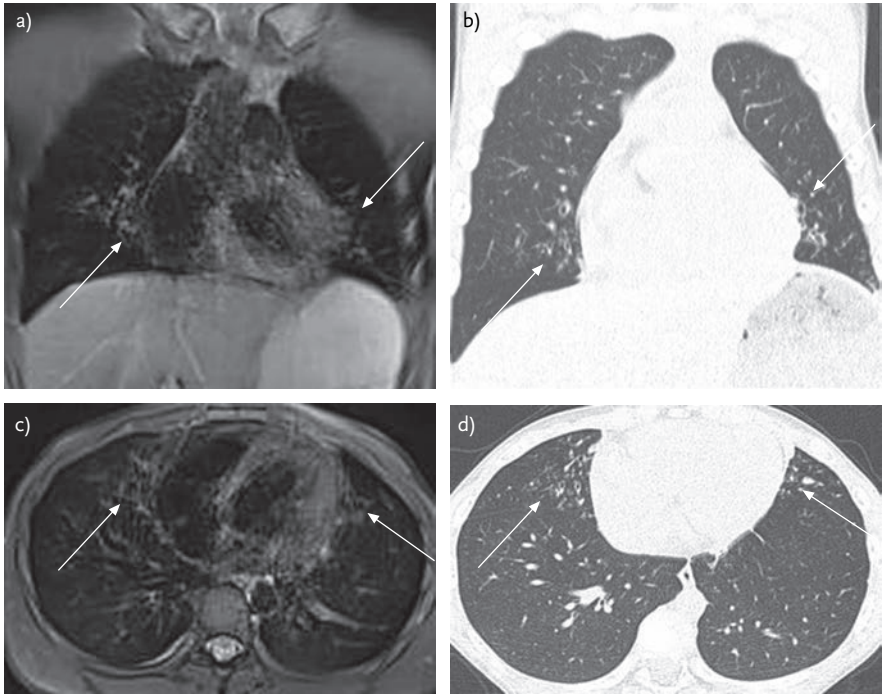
A CT scan from a 9-year-old boy with cough and dyspnoea of b) the coronal and d) the axial plane showed bronchiectatic areas and bronchial wall thickening next to the heart (white arrows). a, c) The same findings are visible on MRI sequences, confirming sensitivity of these protocols for bronchiectasis is at least similar to CT.
